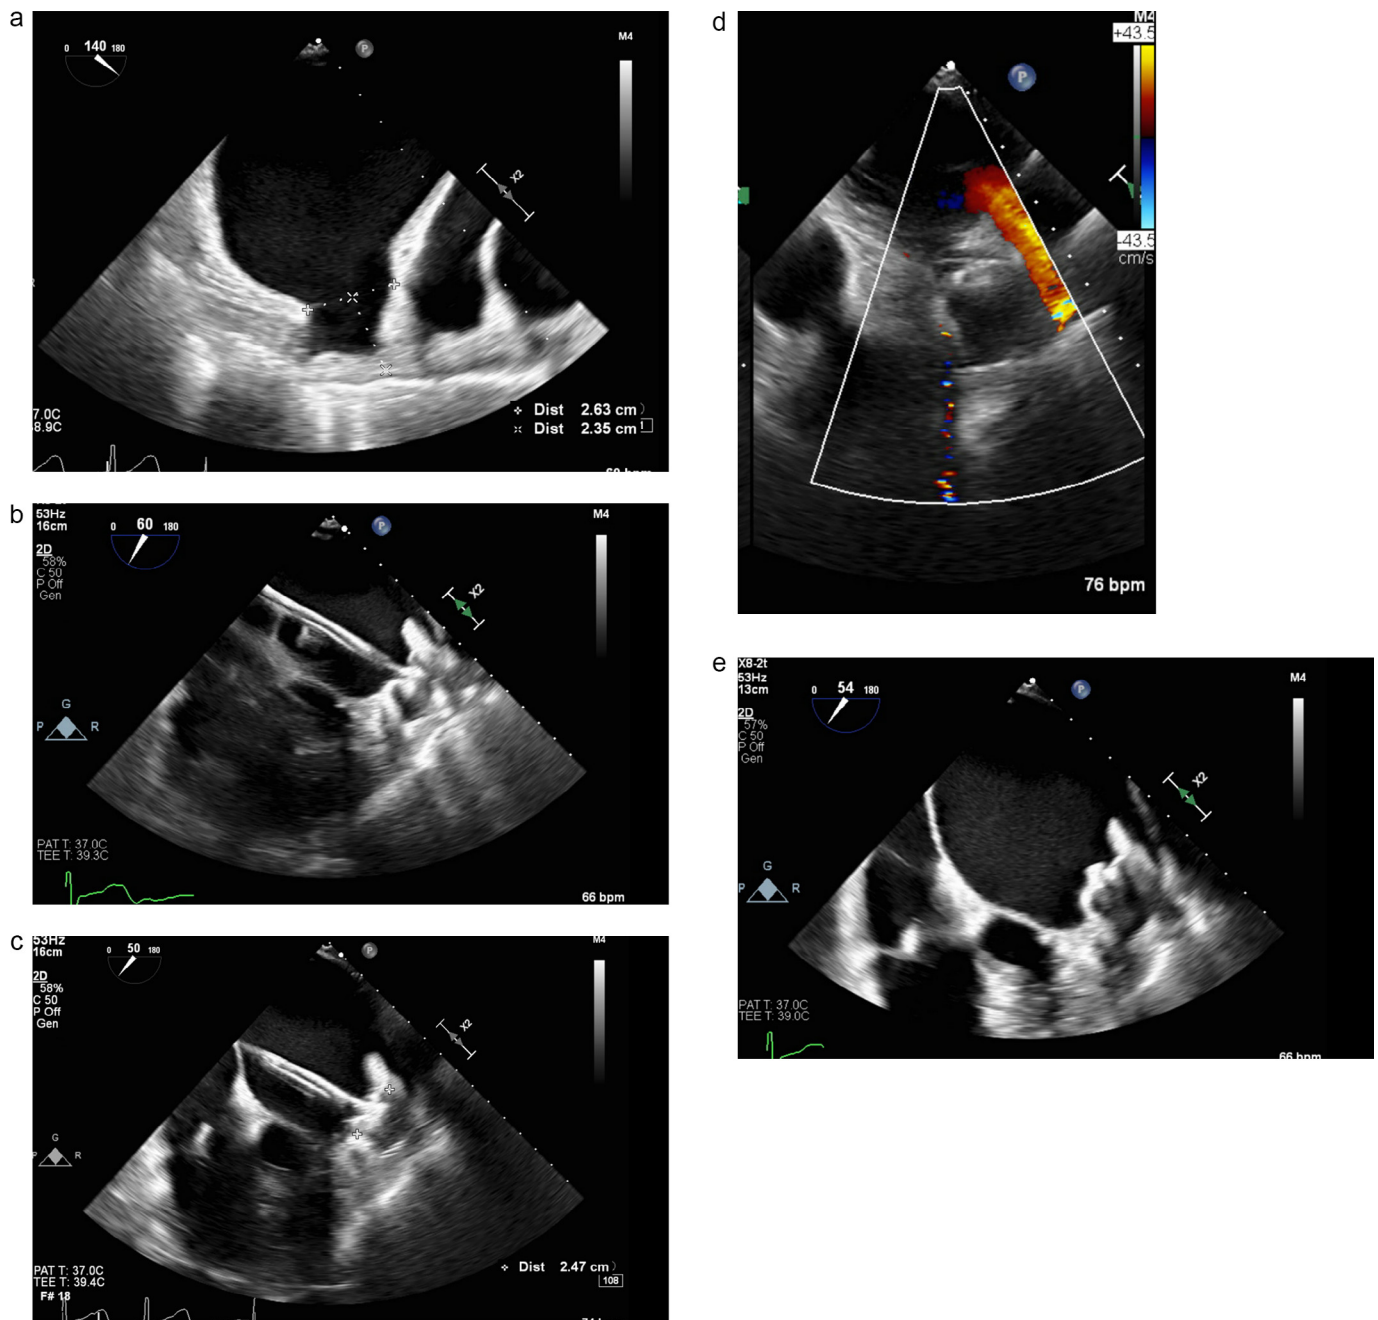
Periprocedural echocardiographic images. a. Pre-device placement with LAA measurement. b. Delivery device in LAA. c. Delivery device in LAA with measurement. d. Post-device placement with Doppler. Note absent color flow in the LAA with flow present in the pulmonary vein. e. Device in place, occluding LAA ostium.
